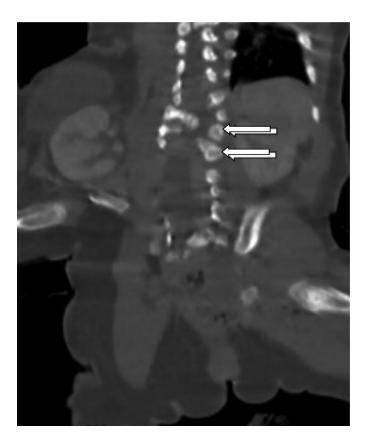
Coronal CT scan bone window showing T12 and L1 hemivertera (white arrows). TASH, 2020.
